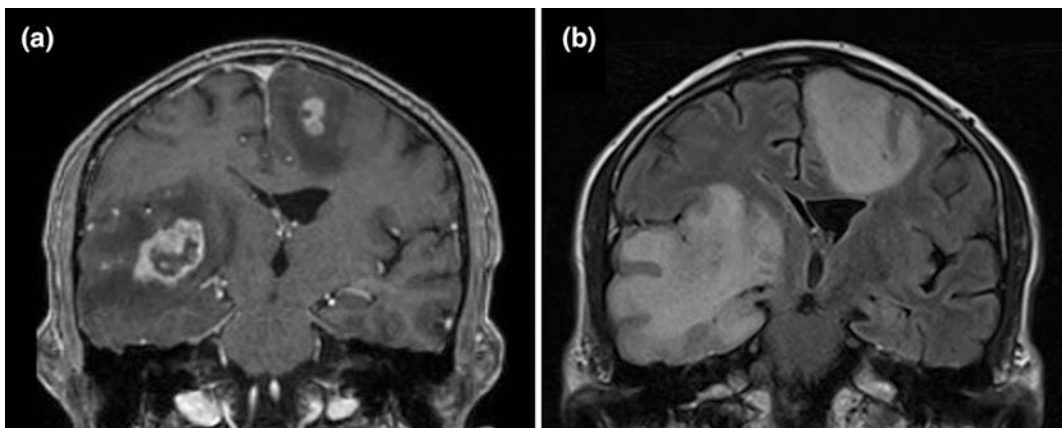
Neuroimaging features of glioblastoma. Magnetic resonance imaging (MRI), T1-weighted gadolinium-enhanced (a), fluid-attenuated inversion recovery (FLAIR, b).
